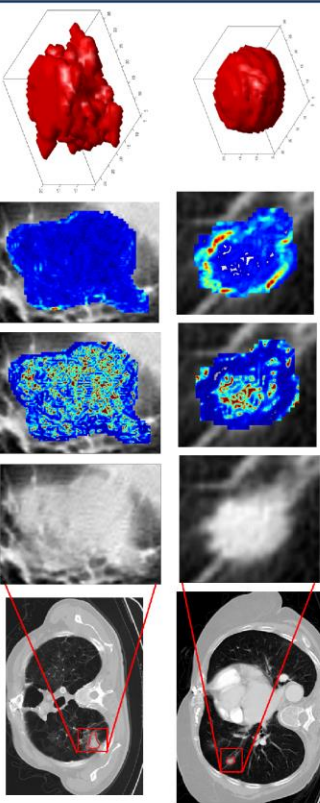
Qualitative demonstration of predictive intra- and peri-tumoral radiomics identified on: (Top Row) Non-Responder and (Bottom Row) Responder. From left to right: Original CT, annotated nodule, Energy texture feature, Difference variance texture feature, sphericity shape feature
